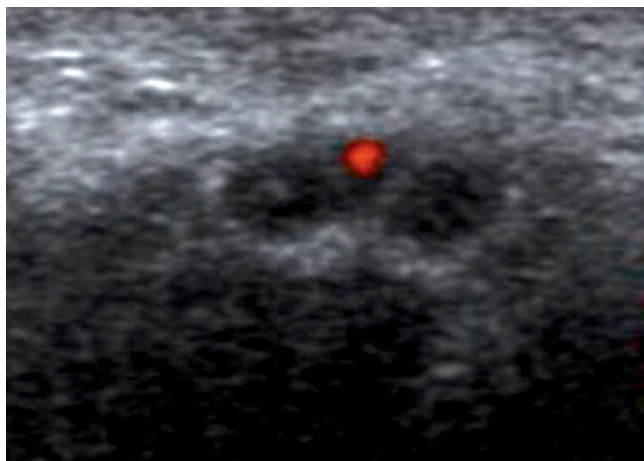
Echo-Doppler. Note the bifid median nerve and the median artery.
